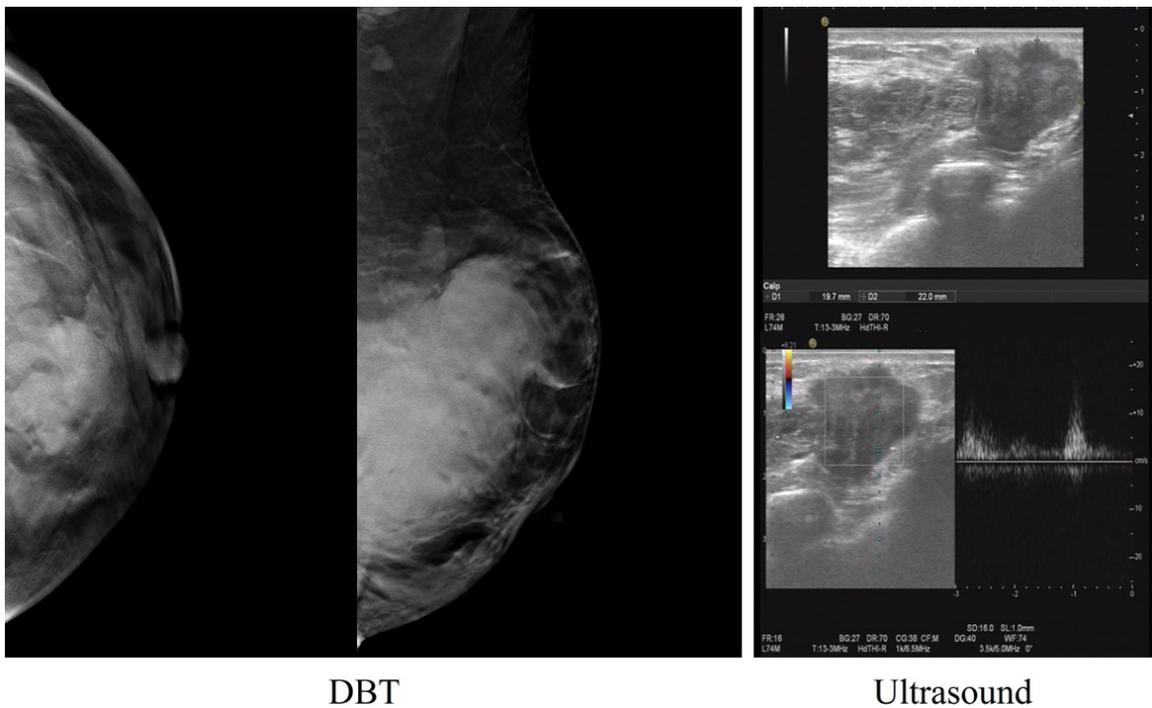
DBT and ultrasound for breast ductal carcinoma after breast augmentation. DBT, digital breast tomosynthesis.
